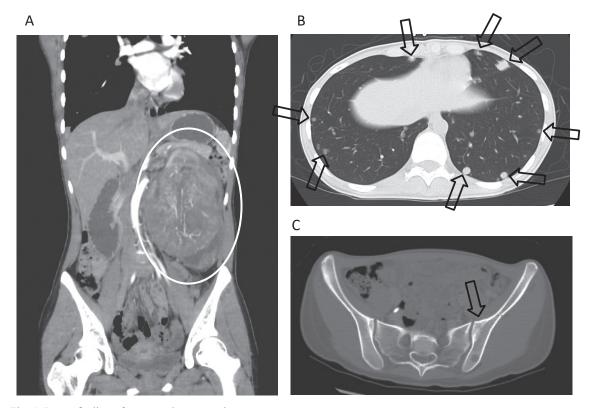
Image finding of computed tomography scan
